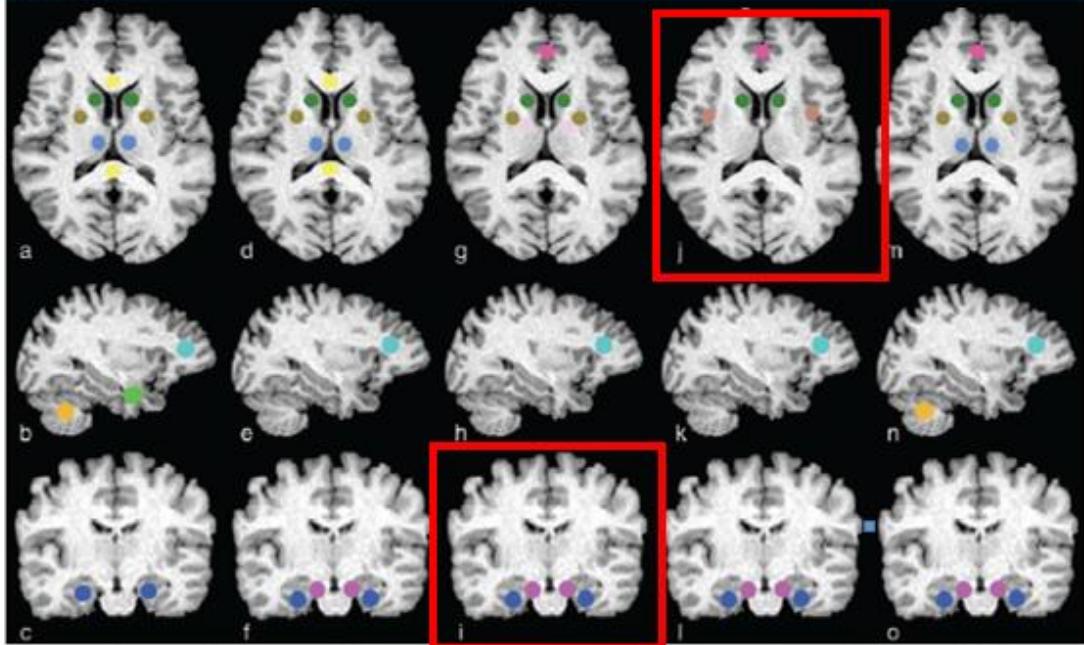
Summary of most reported findings on axial (top row), sagittal (middle row), and coronal (bottom row) MR image sections. (a–c) Findings of schizophrenia: The prefrontal cortex (turquoise), striatum (caudate: dark green, putamen: olive), thalamus (light blue), medial temporal lobe (light green), cerebellum (orange), and corpus callosum (yellow) are key areas of functional, structural, and neurochemical alterations. (d–f) Findings of bipolar disorder: The prefrontal cortex, anterior cingulate cortex (dark pink), striatum, corpus callosum, and limbic structures such as the hippocampus (dark blue) and amygdala (purple) are frequently reported as altered on MR images. (g–i) Findings of major depressive disorder: The prefrontal cortex, anterior cingulate cortex, striatum, basal ganglia (light pink), and limbic structures such as the amygdala and hippocampus are the most reported areas of abnormal structure, function, and neurochemical features. (j–l) Findings of anxiety disorders: The prefrontal cortex, anterior cingulate cortex, caudate, insula (dull orange in *j*), amygdale, and hippocampus are major sites of abnormality. (m–o) Findings of attention deficit–hyperactivity disorder: The prefrontal cortex, anterior cingulate cortex, cerebellum, striatum, amygdala, and hippocampus are the most reported areas of alteration.
